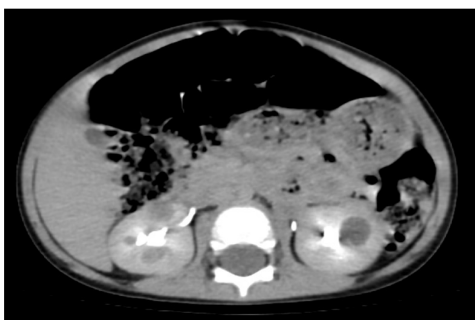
Bilateral cystic formation in the kidneys axial computed tomography image (no kidney stone)
